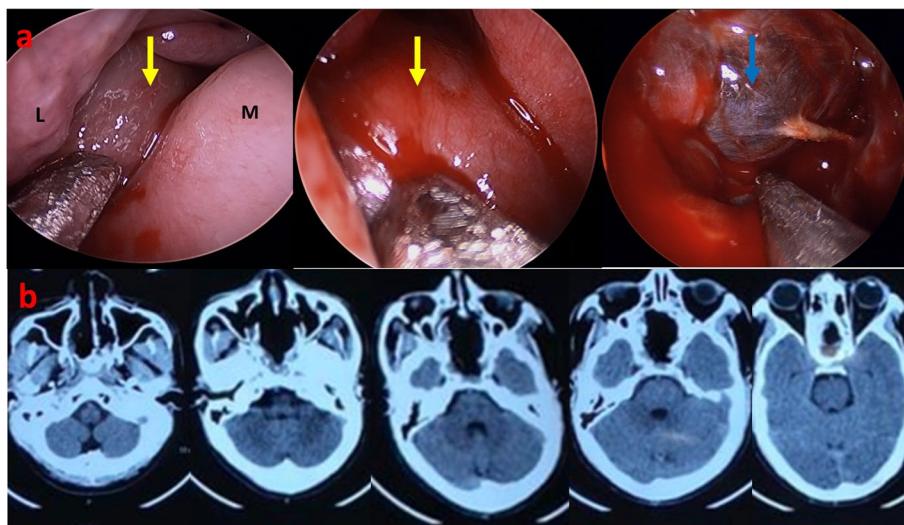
Intraoperative imaging showing the cystic lesion occupying nasal cavity (a). Postoperative CT showing near total excision (b). IT—inferior turbinate, MT—middle turbinate, S—nasal septum. Yellow arrow represents the tumour
